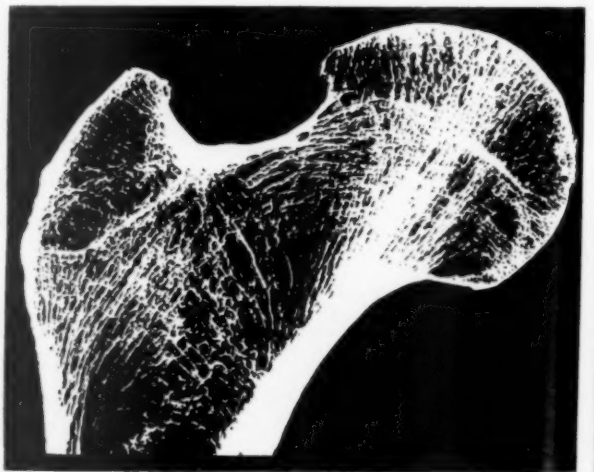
Roentgenograph showing arrangement of trabeculae in head of femur. (From Thompson's "Growth and Form.")
